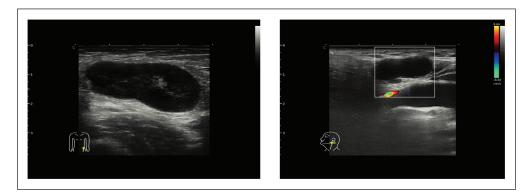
Color Doppler ultrasound of enlarged lymph nodes in groin and neck.
